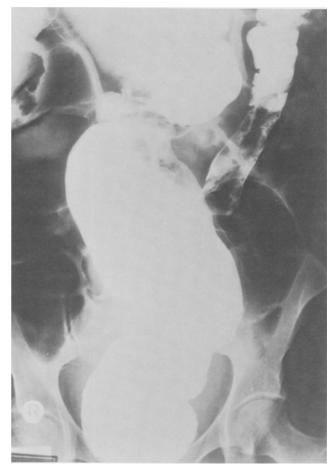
Barium-enema x-ray showing subacute sigmoid volvulus with "parrot beak" deformity.
